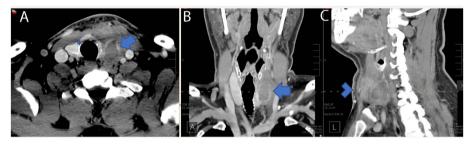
Four weeks post-RFA contrasted neck CT demonstrating a  $3.3 \text{ cm} \times 2.1 \text{ cm} \times 3.5 \text{ cm}$  (AP  $\times$  TR  $\times$  CC) low-density perithyroidal fluid collection with peripheral enhancement (arrow) deep to the sternocleidomastoid muscle with disruption of the anterior capsule (Asterix) associated with edema and reticulation of the overlying subcutaneous tissue and skin (arrowhead) consistent with nodule rupture. Features of the nodule rupture are shown in (A) transverse, (B) coronal, and (C) sagittal planes.
